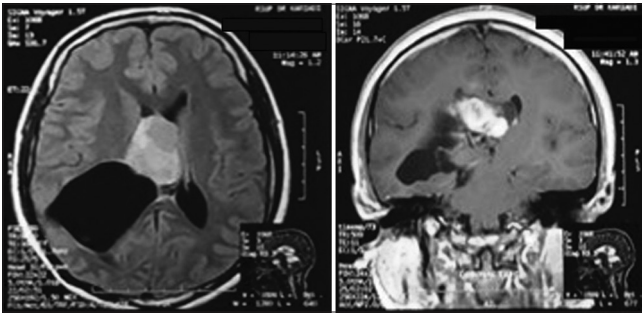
Magnetic resonance imaging 3-month post-radiotherapy (T2: left; T1+C: Right) demonstrated a slight reduction in mass (AP 4.00 × CC 3.86 × LL 3.63 cm)
